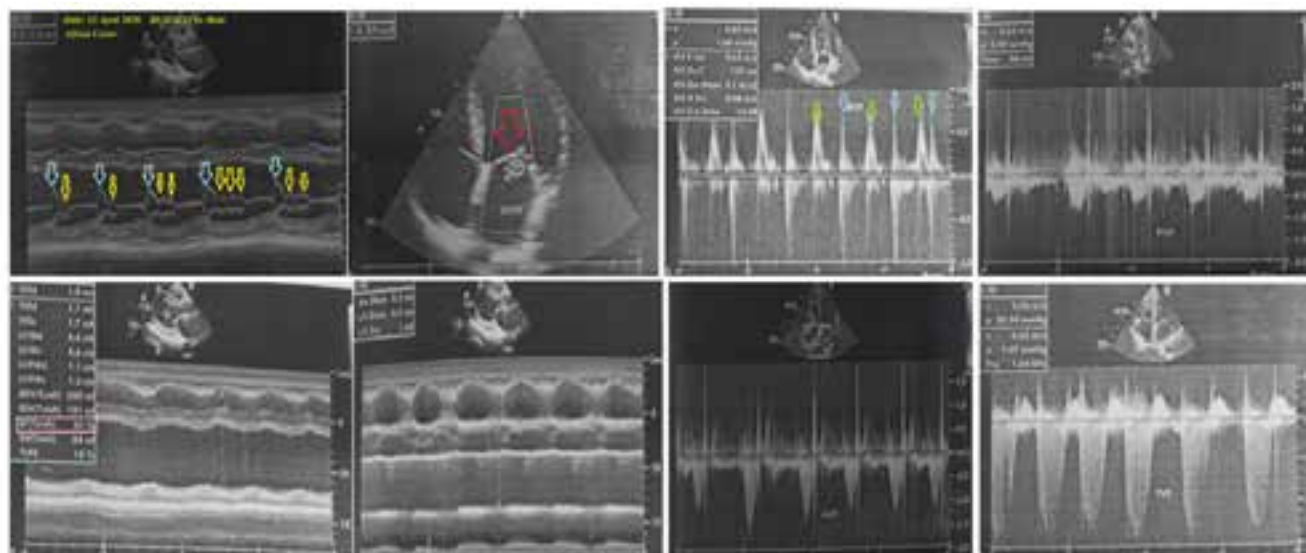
Echocardiography is obtained within 7 days of ICU presentation and after clinical stabilization, showing moderate to severe LV systolic dysfunction, global hypokinesia, LVH, diastolic dysfunction (light blue and lime arrows), mild mitral regurgitation, mild PR, mild TR, and mild pulmonary hypertension, and AF (light blue and lime arrows).
